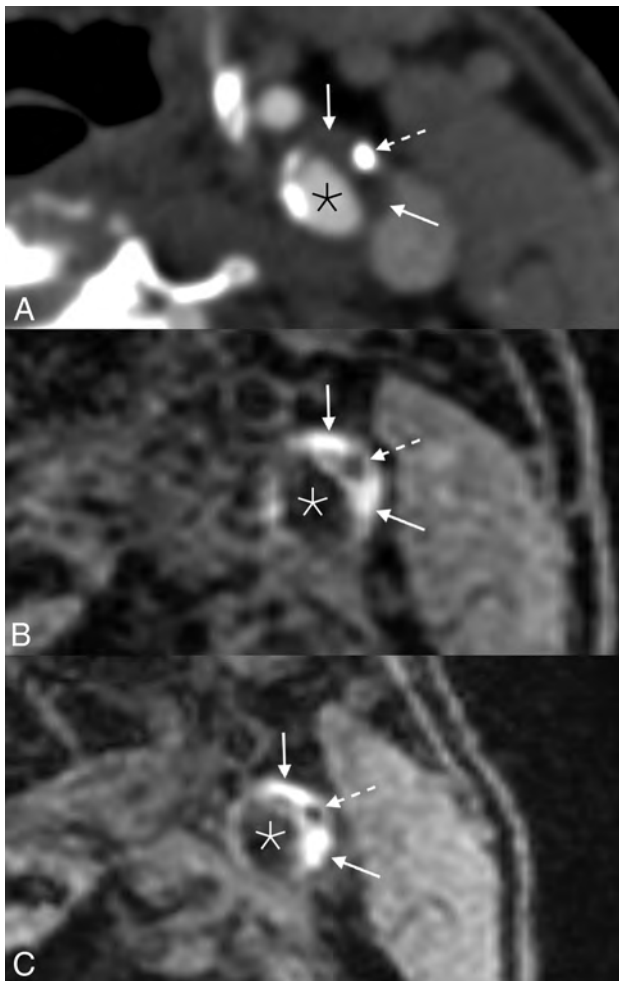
Example of persistent IPH in a 71-year-old man who presented with acute disorientation and unsteady gait. MR imaging of the brain at the time of admission (not shown) demonstrated multiple acute left cerebral infarcts. Axial CTA image (A) shows a mixed calcified (*dashed arrow*) and soft (*solid arrows*) plaque in the left ICA. Corresponding MPRAGE image (B) demonstrates IPH throughout the soft plaque components (*solid arrows*); the focal calcification is also noted (*dashed arrow*). The patient was started on dual antiplatelet therapy (aspirin and clopidogrel). One year later (C), the appearance of the IPH (*solid arrows*) and calcification (*dashed arrow*) was unchanged. Asterisks denote the vessel lumen.
